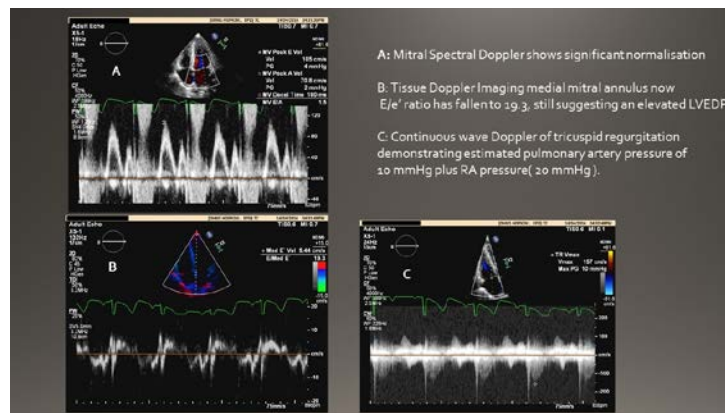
Echo Doppler findings at 48 hours. Panel A: pulsed Doppler mitral inflow. Panel B: tissue Doppler septal annulus. Panel C: continuous wave Doppler tricuspid valve
